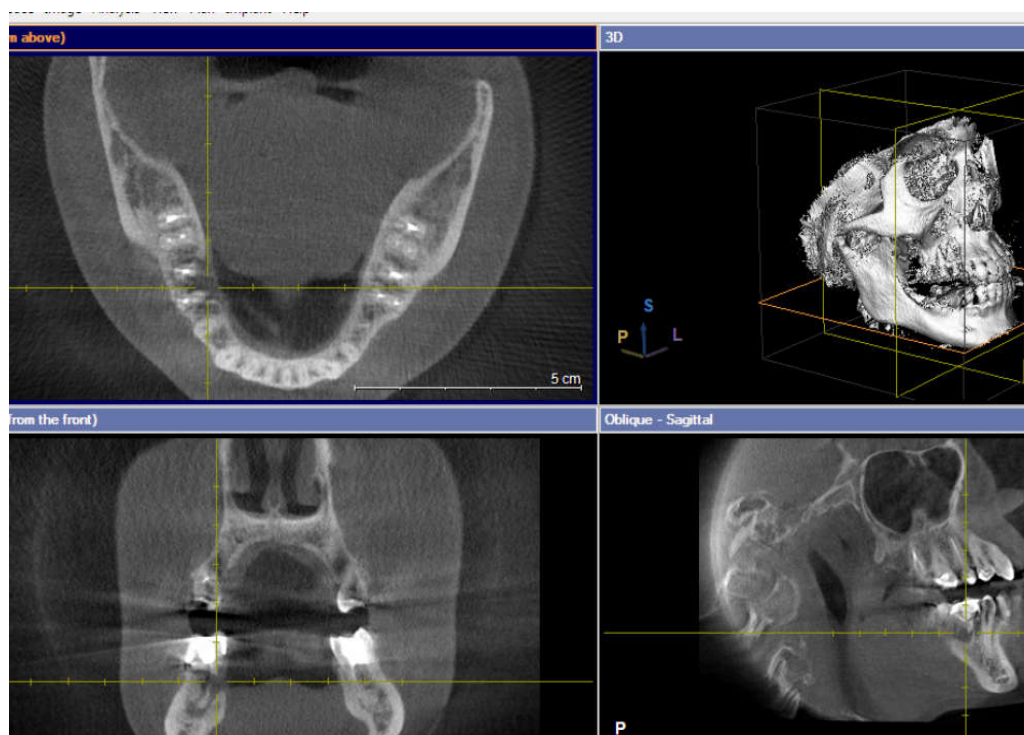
Radiography after 6 months
